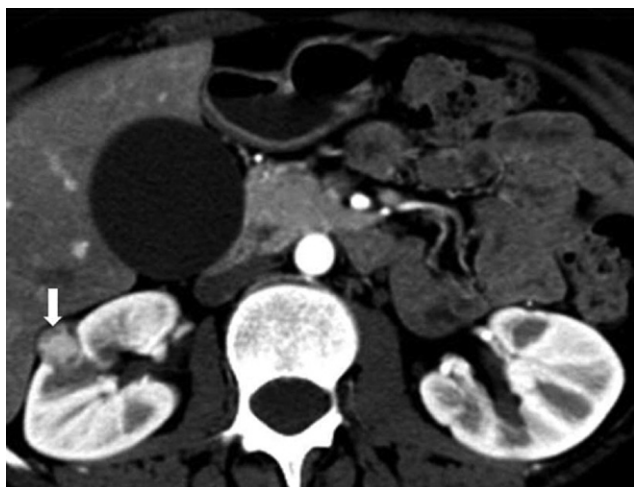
Incidentally detected small clear cell RCC. Contrast-enhanced CT in the corticomedullary phase shows a partially exophytic hypervascular mass (arrow) arising from the anterior interpolar cortex of the right kidney.
